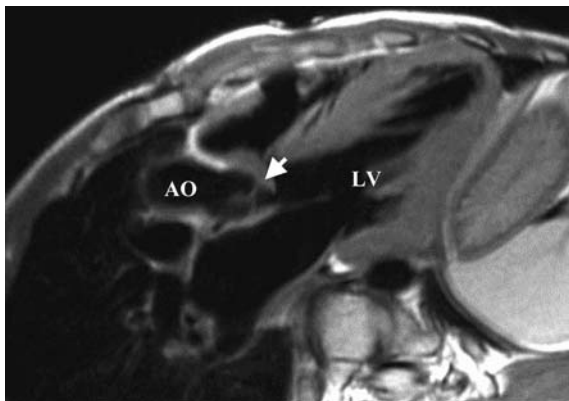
Aortic arch interruption with ventricular septal defect, status post repair. MRI fast spin echo 3-chamber view parallel to the left ventricular outflow tract. Note the severe subaortic stenosis due to posterior infundibular deviation (arrow) (Ao aorta, LV left ventricle)
